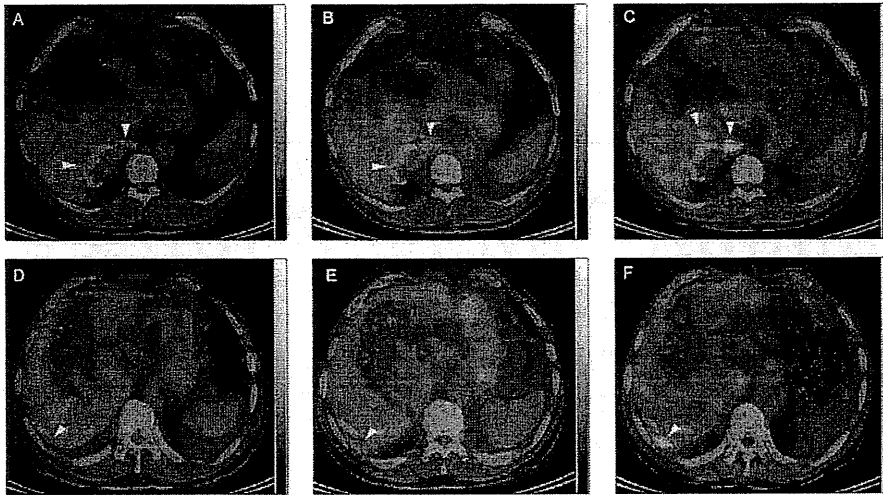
Follow-up of patients with residual/recurrent AE after LT with FDG-PET/CT in (A-C) patient 1 and (D-F) patient 3. (A) Follow-up FDG-PET/CT scan 19 years after LT: no FDG uptake by AE lesions. (B) Follow-up FDG-PET/CT scan 22 years after LT: no abnormal uptake 1 hour after the injection. (C) Two foci of perilesional FDG uptake in the liver 3 hours after the injection (arrowheads). (D) Follow-up FDG-PET/CT scan 17 years after LT: no FDG uptake 1 hour after the injection and a decision to withdraw ABZ. (E) Follow-up scan 2 years after ABZ withdrawal and 19 years after LT: no FDG uptake 1 hour after the injection. (F) Perilesional FDG uptake in the liver (arrowheads) 3 hours after the injection and a decision to reintroduce ABZ.
